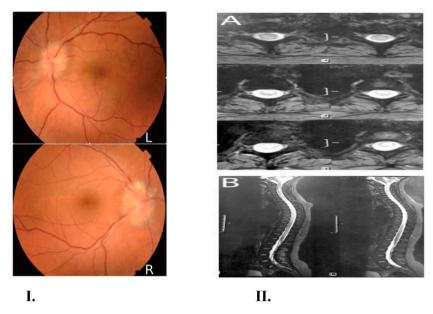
Case 10: I. Funds examination showing bilateral papillary edema stage 3; II. Sagittal (A) and axial (B) T2 Weighted MRI showing high signal intensity throughout the cervical, thoracic and lumbosacral cord.
